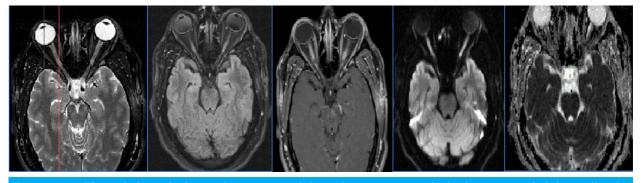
a) T2 axial shows high signal intensity in bilateral optic nerves which also appear slightly swollen b) FLAIR axial image demonstrates hyperintense signal in bilateral optic nerves c) T1 axial post contrast images show enhancement of the optic nerves d & e) DWI and ADC image show diffusion restriction in bilateral optic nerves as well as optic nerve head. (Images previously published in AJNR case of the week on January13, 2022)
